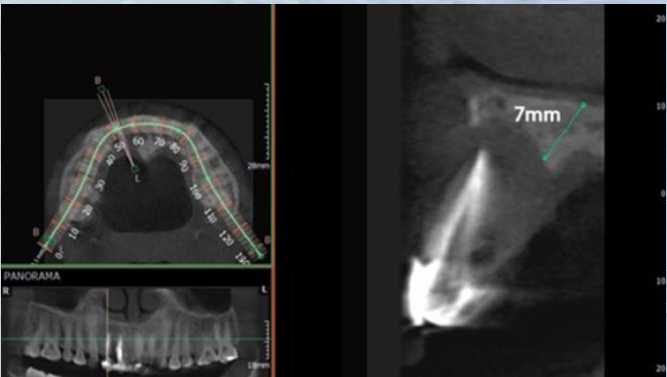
Pre-operative CBCT extensive bone loss
